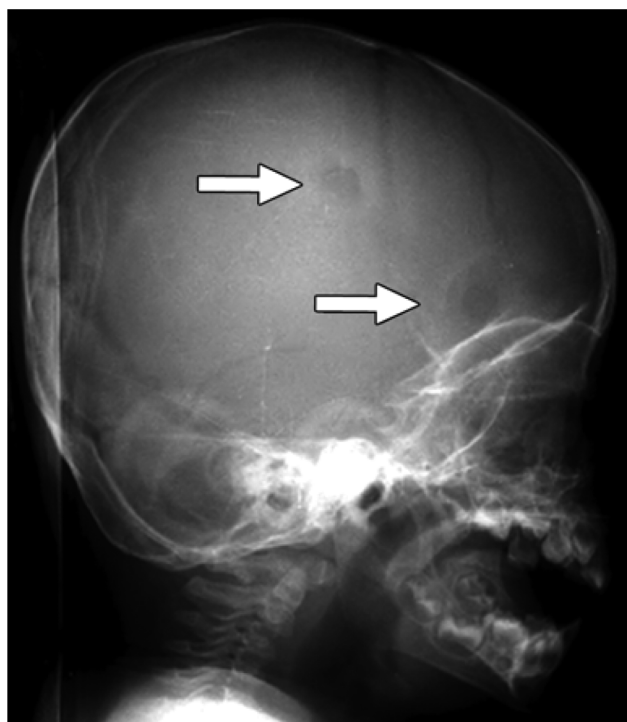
Lateral skull radiograph shows two well-defined lytic lesions (*arrows*) with characteristic beveled edges.
